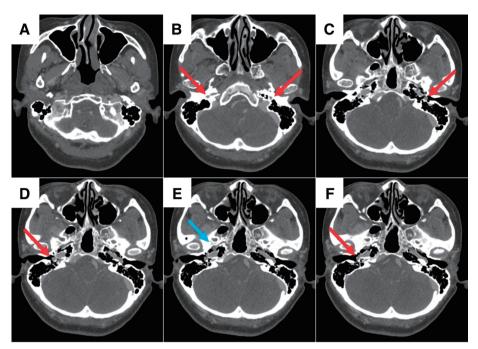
Axial section of contrast-enhanced CT (A–F, caudal to cranial). In slice (B), the lateral limb of the right duplicated ICA and the left aberrant ICA are seen ascending to traverse the tympanic cavity through a dilated inferior tympanic canaliculus (Jacobson's canal) (red arrow). Slice (C) shows intratympanic aberrant ICA (C, D, F, red arrow). Slice (E) demonstrates an absent right foramen spinosum, indicating the presence of a PSA (blue arrow). In slice (F), the lateral limb of the right duplicated ICA and the left aberrant ICA traverse the tympanic cavity and enter the proximal portion of the carotid canal within the petrous bone. ICA, internal carotid artery; PSA, persistent stapedial artery
